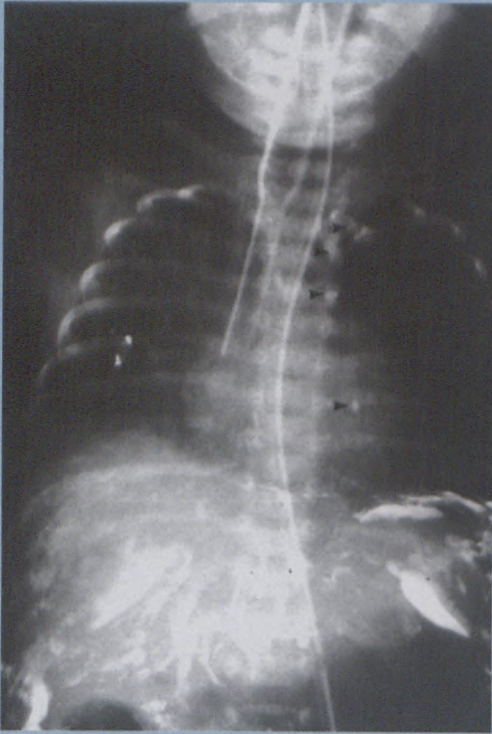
Post-operative anterior-posterior chest radiograph demonstrates barium coating the peritoneal surface and located as several foci along the left sternal border (arrowheads).
